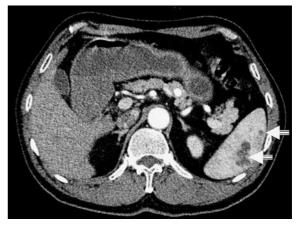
Plain abdominal computed tomographic scan showing multiple small cysts (arrows) in the red pulp of the spleen.
